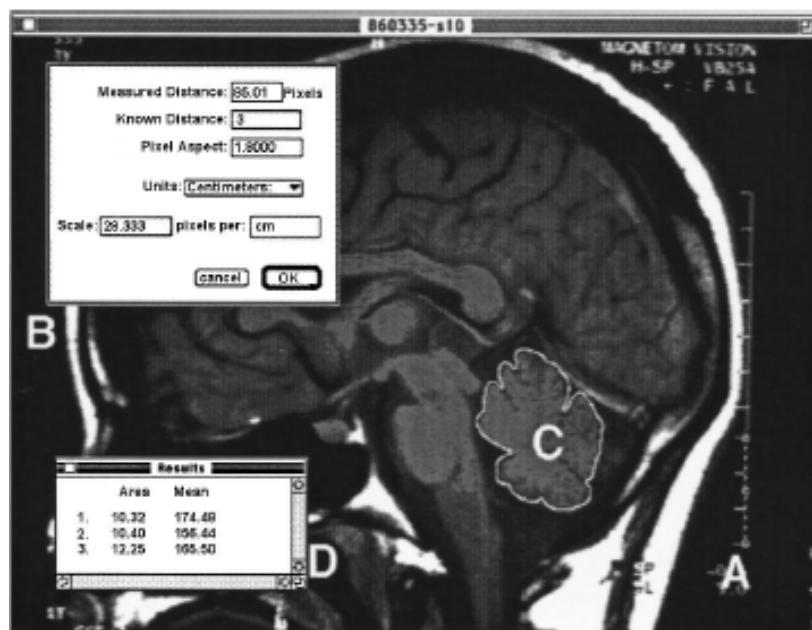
Captured screen of NIH image 1.60 for MRI analysis: Segmentation of midsagittal vermis and total cerebellum slice. Adapted from Rhyu *et al.* (1999b)
